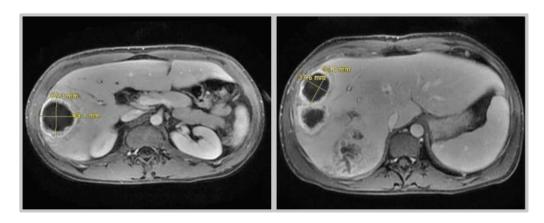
MRI of the abdomen showing pyogenic right-sided liver abscesses with rim enhancement.
